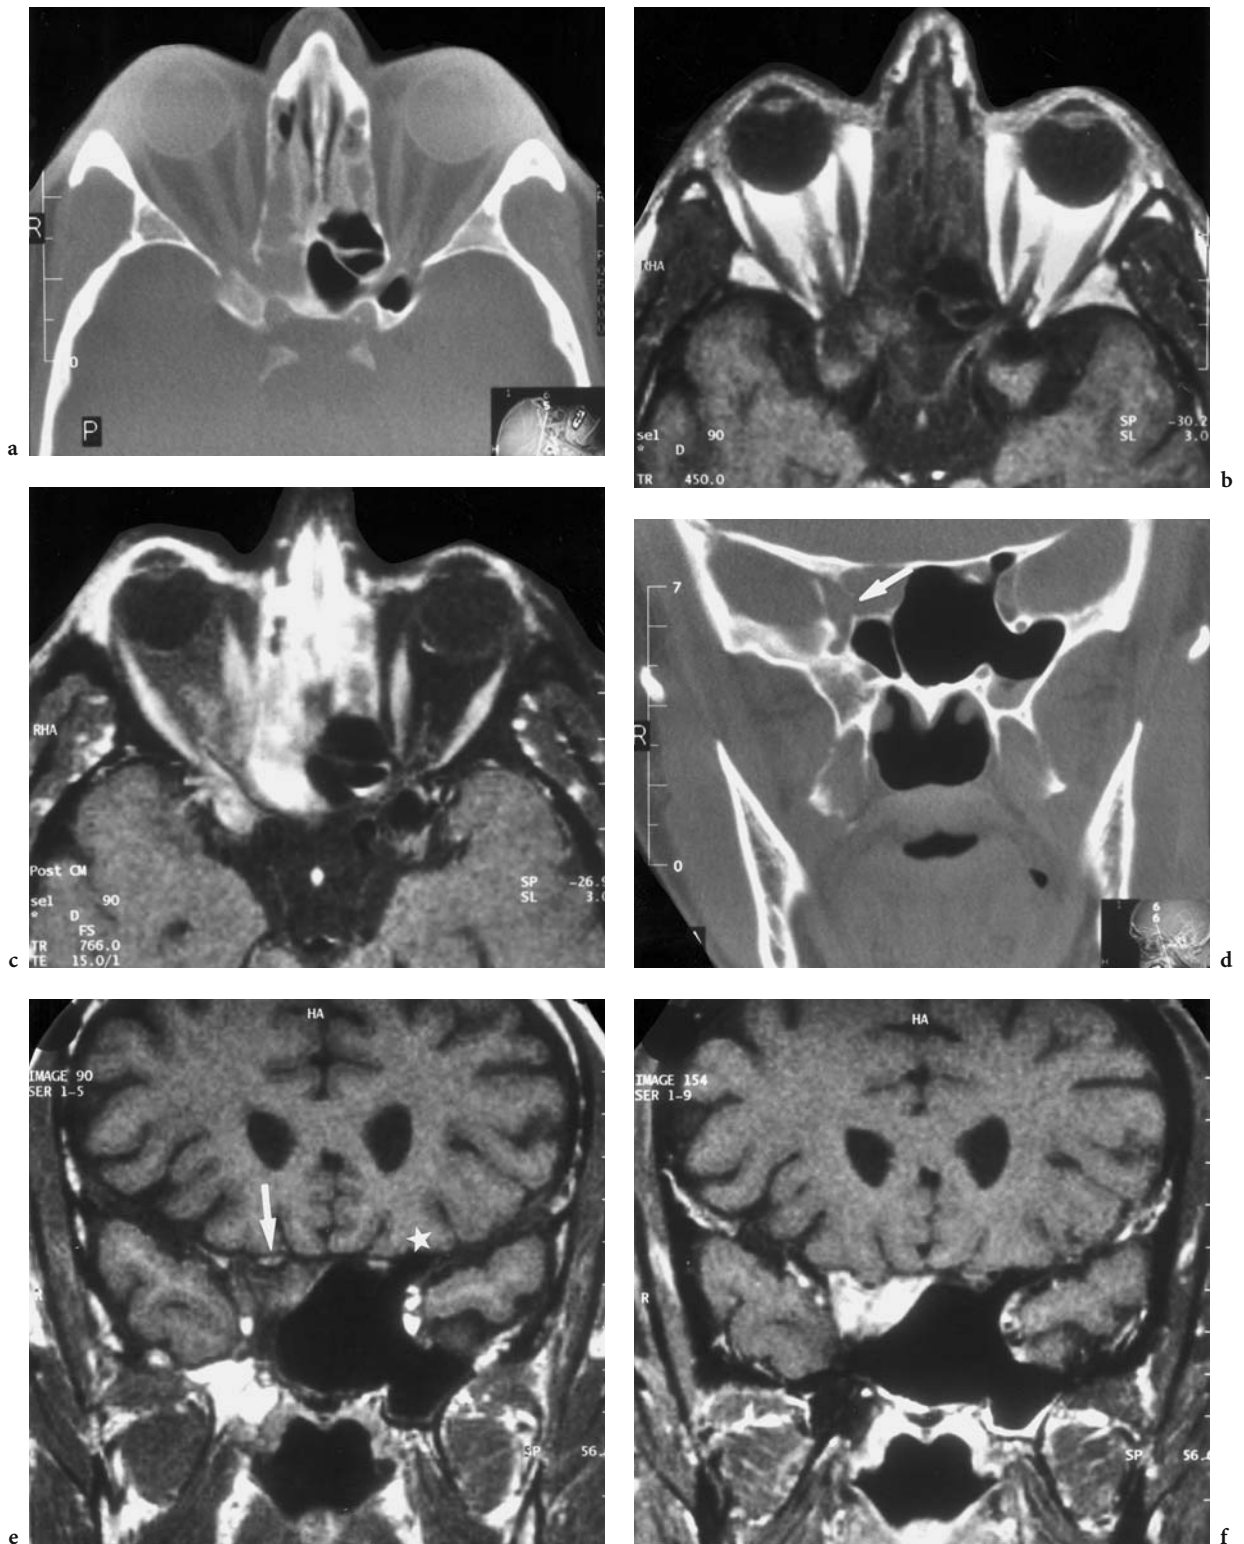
A 55-year-old man with diplopia of the right eye, N IV and N VI paresis, and a history of recently ethmoidal cell operation, in the absence of visual problems. Diagnosis: secondary orbital apex inflammation of an ethmoidal mucocele. a Axial CT in bone window of the orbital apex and optic canal, showing the irregular destruction of the medial wall of the right optic canal, originating from the ipsilateral, shadowed sphenoid sinus. b Corresponding T1-weighted native MRI. c Corresponding T1-weighted, contrast-enhanced (FS) view, showing signal enhancement of the intrasphenoidal mass. d Coronal CT showing the destruction of the medial wall of the superior orbital fissure (*white arrow*). e Corresponding T1-weighted native MRI with an isointense mass in the right lateral sphenoid sinus, inferior to the right optic nerve located in the nerve canal (*white arrow*). As a symmetric pneumatization might be expected of the right anterior clinoid process as compared with the left (*white star*), involvement of the described part of the sphenoid sinus is apparent (compare with d). f Corresponding T1-weighted, contrast-enhanced (FS) view
